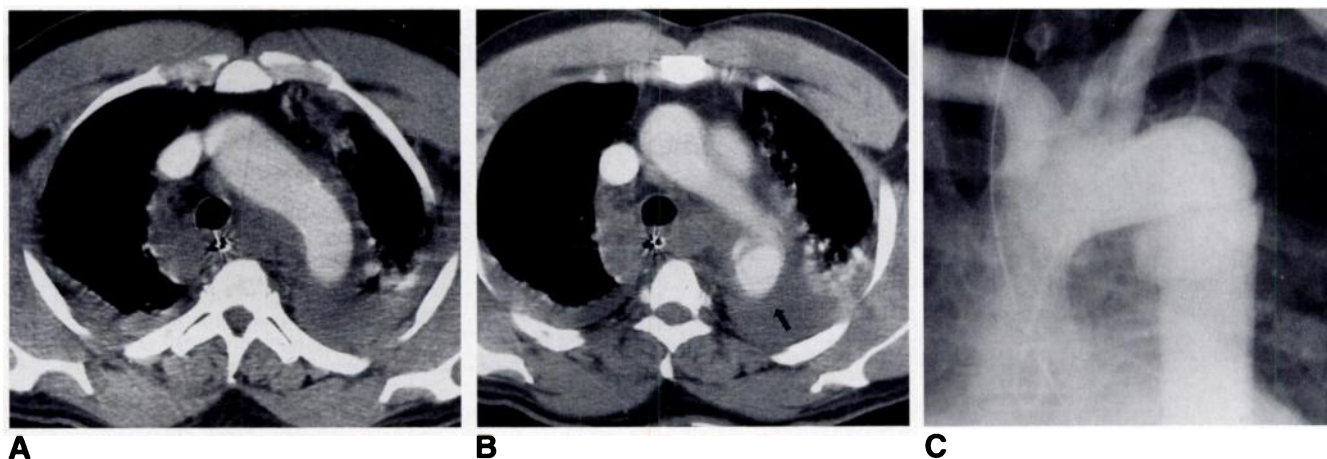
Mediastinal hematoma and false aneurysm of thoracic aorta in a 62-year-old man who was injured in a high-speed motor vehicle accident. A, Contrast-enhanced CT scan of chest shows diffuse homogeneous increased density (hematoma) surrounding aortic arch, trachea, and esophagus. B, Contrast-enhanced CT scan 2 cm lower shows a large false aneurysm (arrow) at level of isthmus. C, Thoracic aortogram in left anterior oblique projection also shows false aneurysm and associated laceration.
